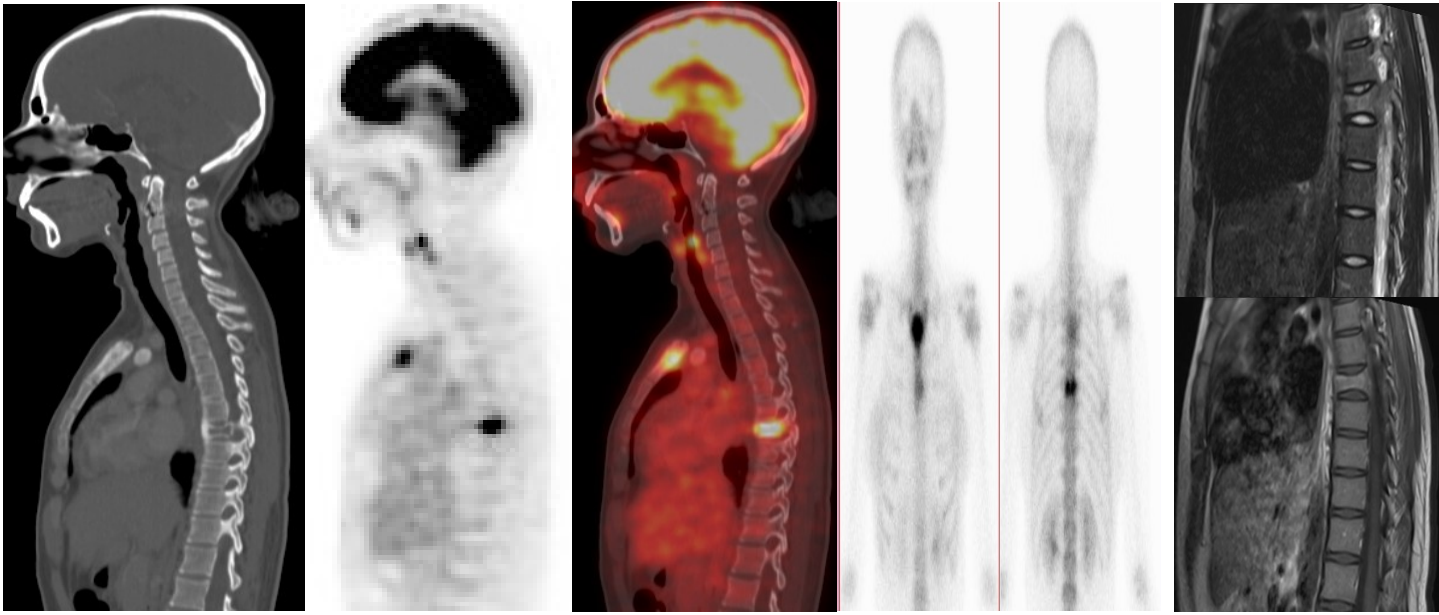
Initial pretreatment PET/CT revealed metabolically active FDG avid osseous infiltrate at DV7 and manubrium sterni.; Bone scan images revealed two active osseous lesions at DV7 and manubrium sterni. ; MRI spine T1 and T2 sagittal images: confirmed DV7 infiltration.
